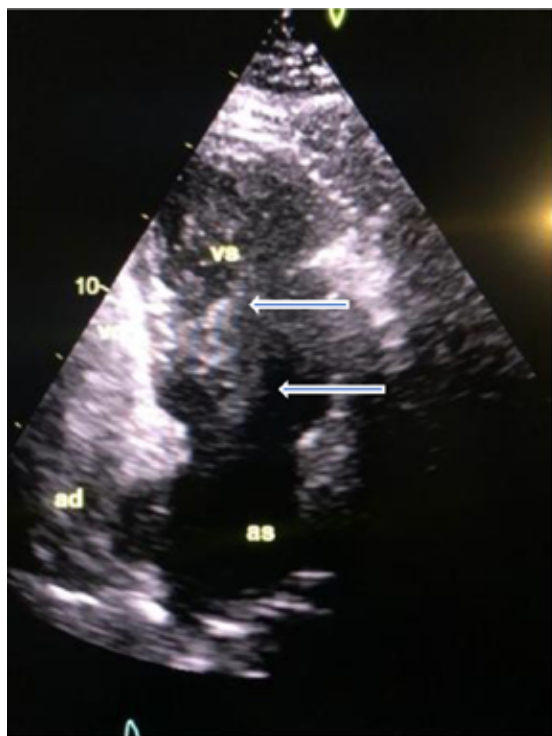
Contrast echocardiography: contrast material in the left ventricle (arrows) as a consequence of right to left atrial shunt.
